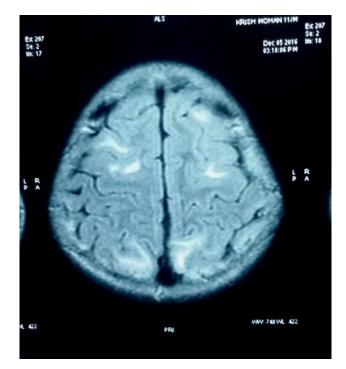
MRI scan showing white matter edema in bilateral frontoparieto-occipital regions in case 2
